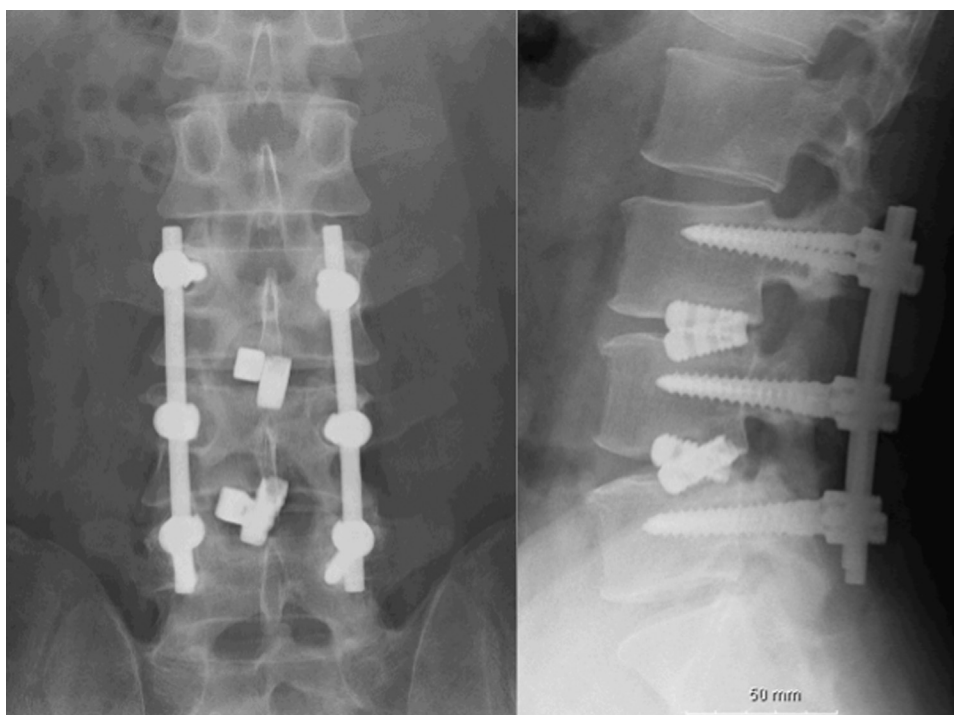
Preoperative plain X-ray. Anteroposterior and lateral views of patient 1 showing L3-5 PLIF without autologous bone graft. Subsidence of the intervertebral spacer and loosening of the pedicle screws are evident.
